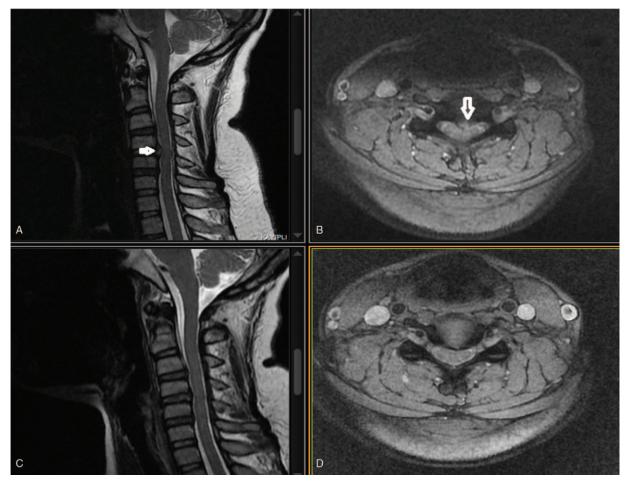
Of case 3, (A, B) Sequestered CDH on sagittal and axial spinal cervical MRI on admission (white arrow). (C,D) Resorption image of the disc on control spinal cervical MRI. CDH = cervical disc herniation.
